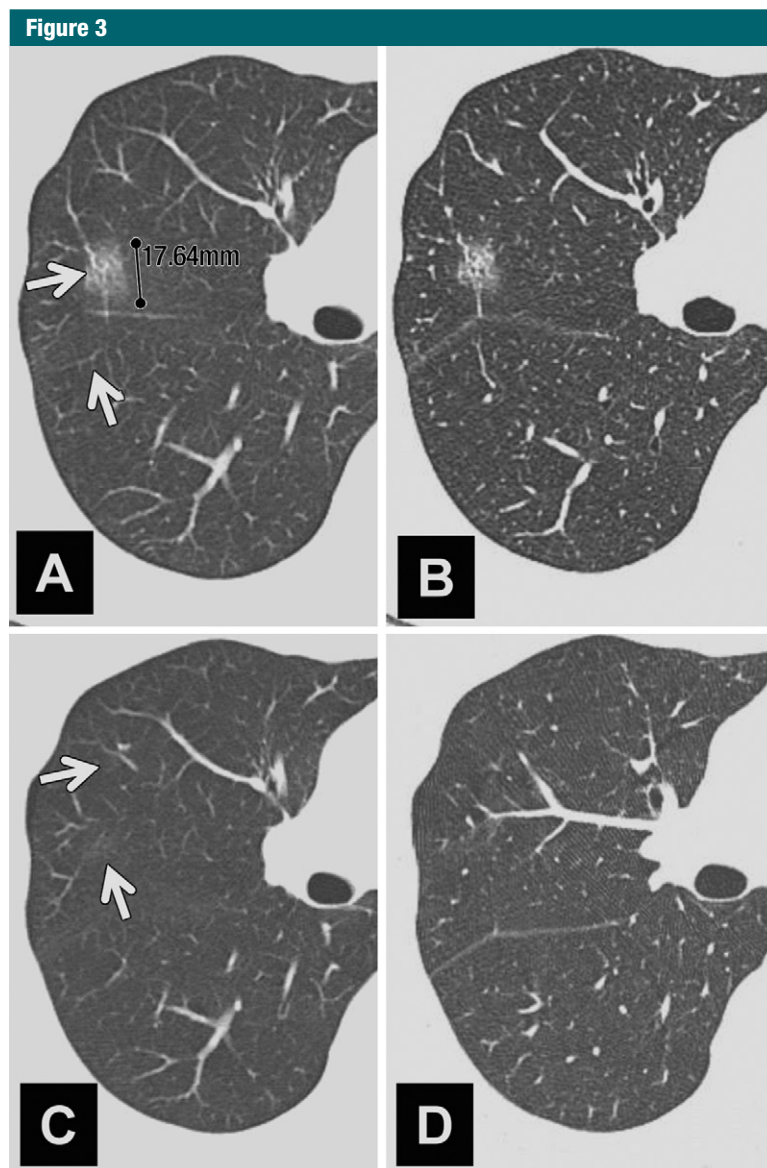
Value of initial short-term follow-up of benign GGNs. *A, B*, Target reconstructed 5-mm-thick (*A*) and 1-mm-thick (*B*) sections through right upper lobe show a focal ground-glass lesion (upper arrow in *A*), within which a few dilated peripheral airways can be identified. This appearance is strongly suggestive of a peripheral adenocarcinoma. Lower arrow in *A* points to normal lung. *C, D*, CT scans obtained with 5-mm-thick (*C*) and 1-mm-thick (*D*) sections 3 months later at same level as *A* and *B* show near-complete disappearance of lesion, likely representing focal nonspecific inflammation. Arrows in *C* indicate subtle new foci of ground-glass attenuation appearing in the interval, again consistent with nonspecific inflammation.
